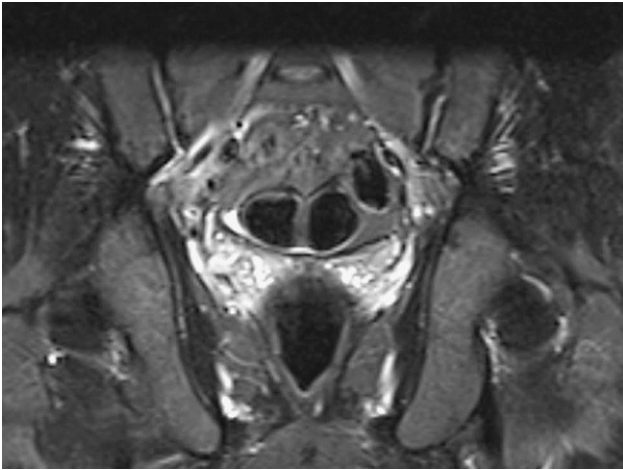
Coronal section of pelvic MRI on T2 STIR sequence on admission, with no pathological findings in either sacroiliac joint.
